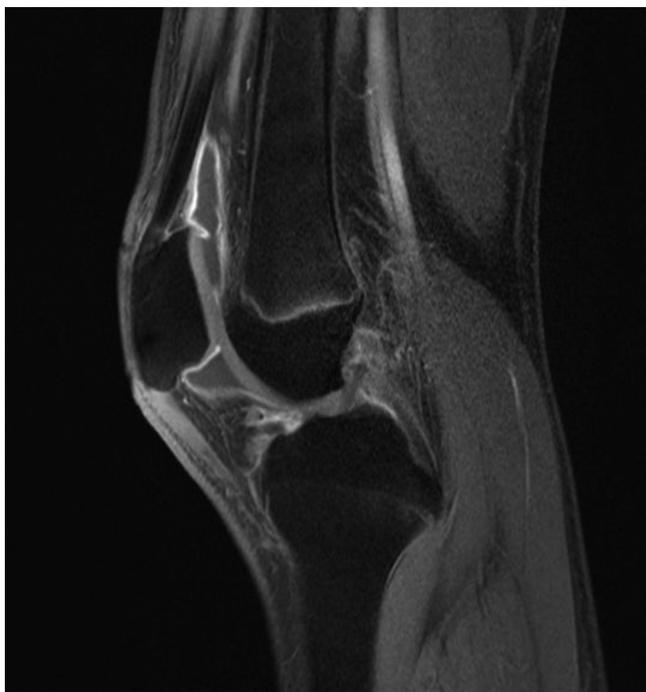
Sagittal T1 weighted fat-saturated magnetic resonance imaging images, post yttrium-90 therapy 2.8 mCi (millicurie)
